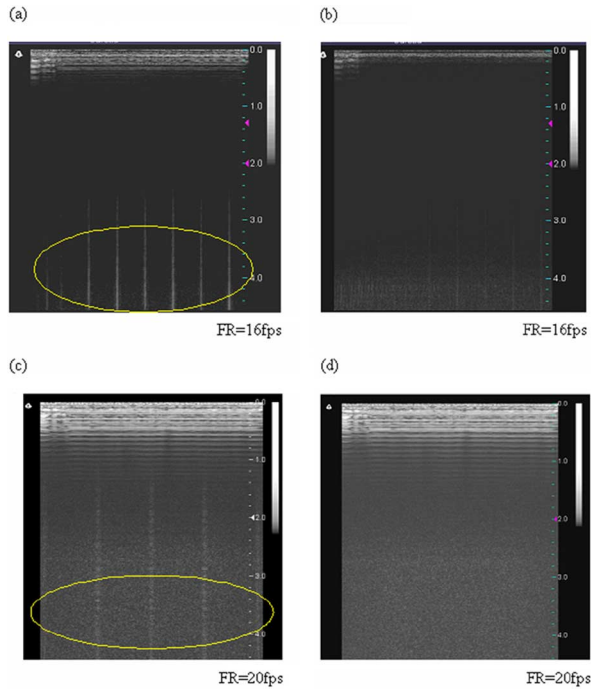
US images with probe at isocenter of 3 T MRI system while MRI is running with [(a), (b)] TR= 800 ms, and [(c), (d)] TR= 600 ms. (a), (c) With US probe window unshielded. (b), (d) US probe window shielded with a single layer of foil. Yellow ellipse indicates the vertical strips at the bottom.
